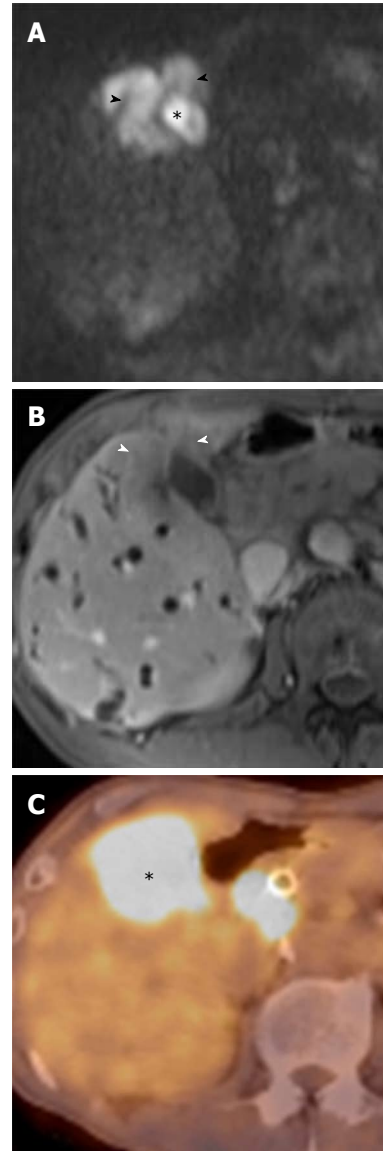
Gallbladder carcinoma in a 70-year-old man. A: DWI at $b = 1000 \text{ s/mm}^2$ shows high signal intensity in the mass occupying the entire gallbladder (asterisk), which invades the hepatic parenchyma adjacent to the gallbladder (arrowheads); B: Gallbladder carcinoma with direct liver invasion (arrowheads) is less conspicuous on contrast-enhanced, fat-saturated T1-weighted images than on DWI; C: Fused positron emission tomography-CT image confirms intense hypermetabolism (asterisk) in the gallbladder carcinoma with direct liver invasion adjacent to the gallbladder. DWI: Diffusion-weighted magnetic resonance imaging; CT: Computed tomography.
